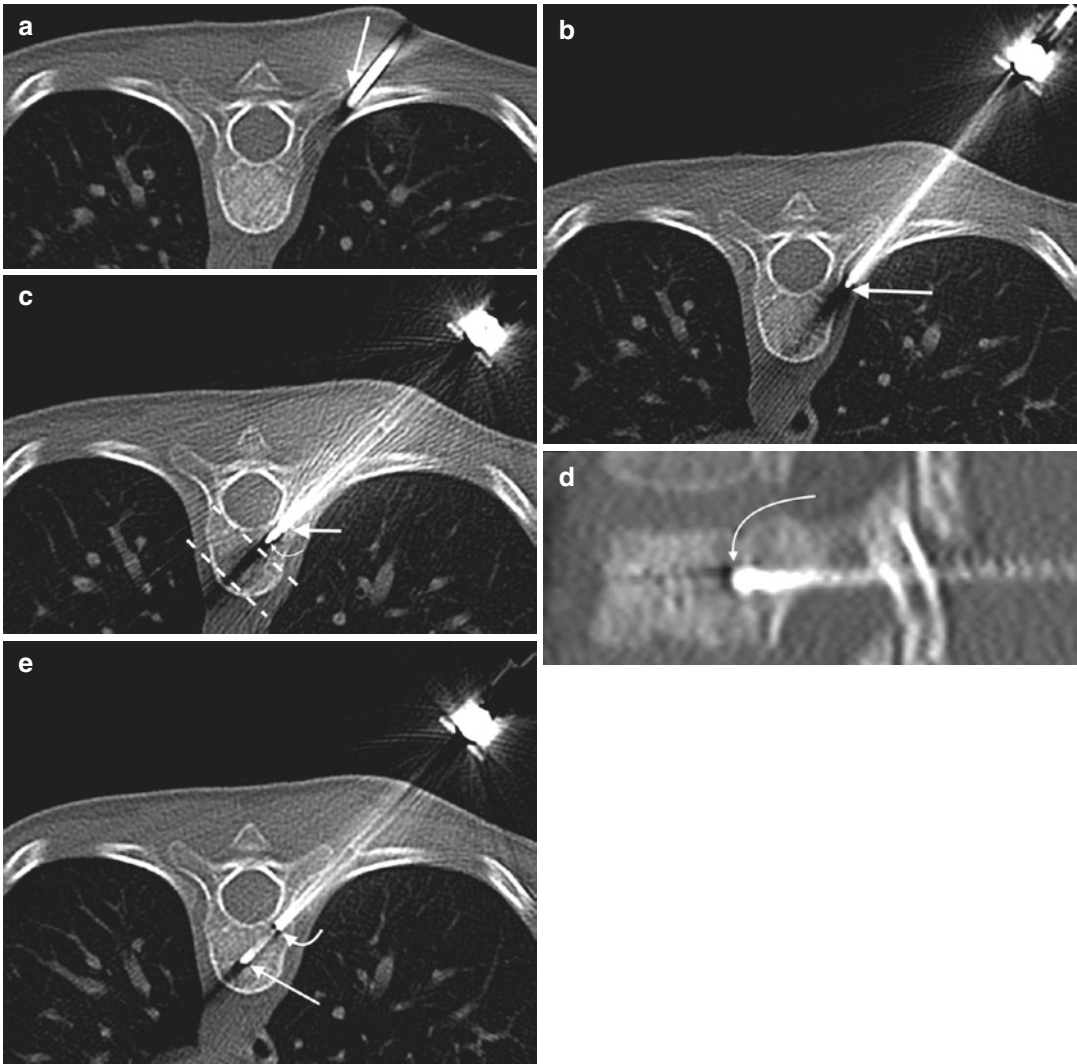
A 7-year-old female with back pain, 1 month later. Axial CT image (a) from a T9 biopsy procedure shows advancement of a bone needle via a costotransverse approach (arrow). Axial CT image (b) shows needle tip at lateral margin of vertebral body (arrow); because of the steep nature of this approach, the needle tip points at the vertebral body, not the lung. Axial CT image (c) shows entry of the bone needle (curved arrow) into the posterior vertebral body. The beam hardening artifact distal to the needle provides a good estimate of the needle trajectory within the remainder of the vertebral body (dashed lines);
